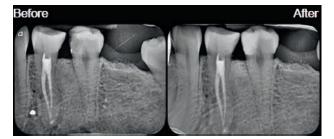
X-ray before and after direct pulp capping.
